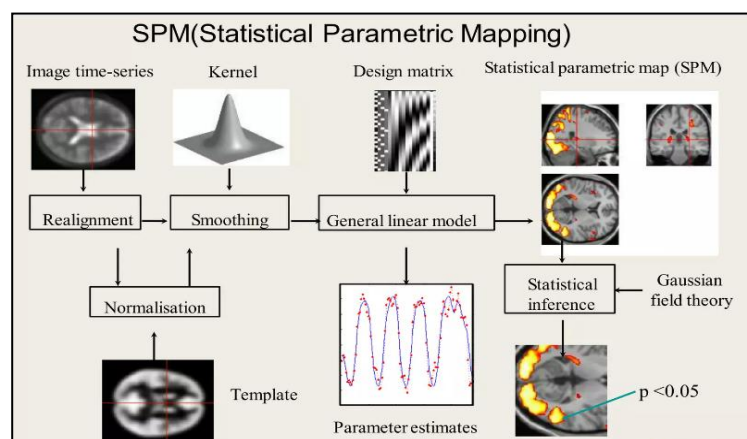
MRI Brain Image Processing Flow In SPM
